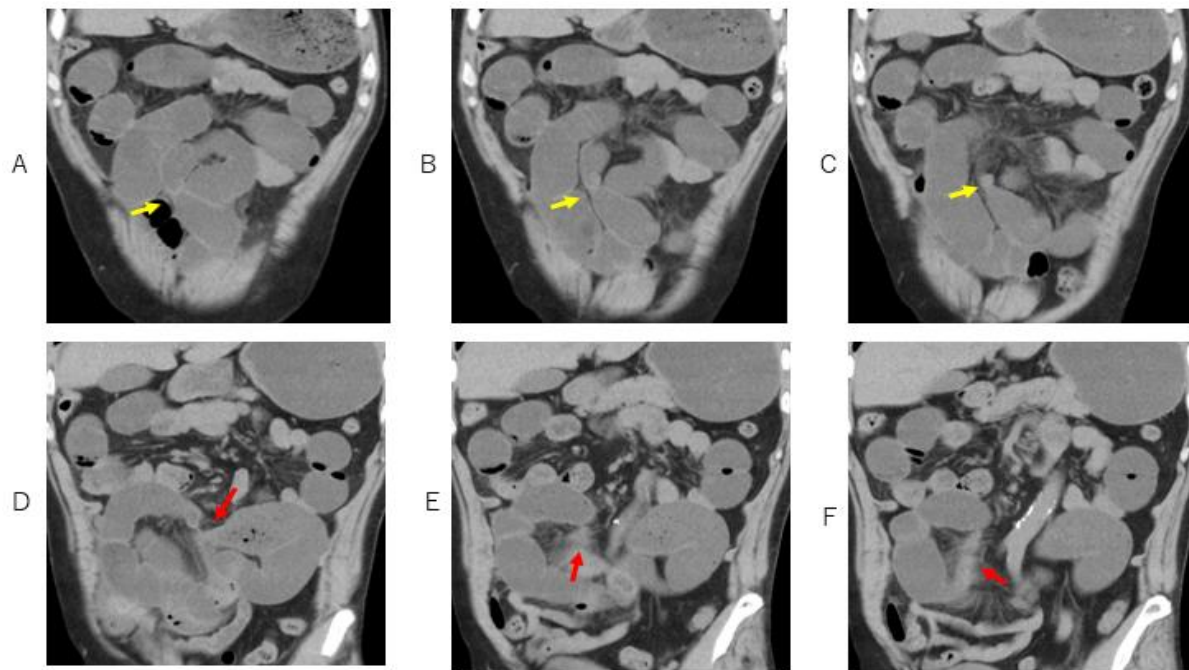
Two beak sign or two knot sign is depicted on coronal CT (arrows). One is the occlusive transposition site between oral dilated bowel and oral dilated closed loop (A-C, yellow arrow), and another is the transposition between anal closed dilated loop and constrictive anal bowel (D-F, red arrow). Yellow knot is tight, while red knot is relatively loose.
